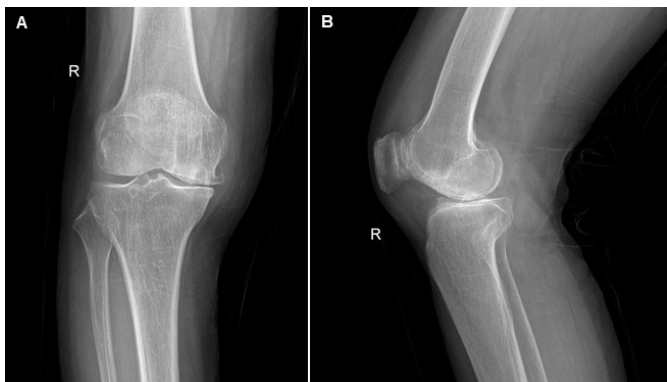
Preoperative radiographs. (A) Anteroposterior and (B) lateral views showing isolated medial osteoarthritis.
